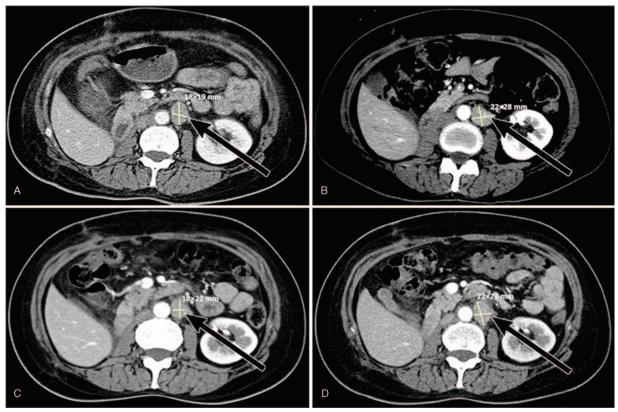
Contrasted CT scans during sunitinib rechallenge therapy after the second surgery. (A) Baseline of sunitinib rechallenge with 50 mg in standard schedule. (B) The patient had a progression disease 3 months after the second surgery, and the tumor size was 22×28 mm. (C) A shrinkage was detected after 2 cycles of sunitinib elevating to 62.5 mg (18×22 mm). (D) The latest CT scan showed the metastatic lymph nodes were stable about 12 months after elevation of sunitinib to 62.5 mg (22×23 mm).
